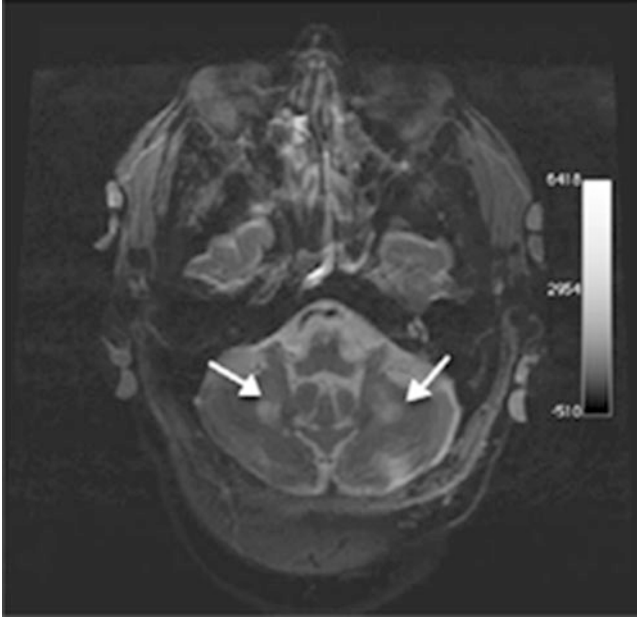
T2-weighted axial image of the brain of a 65 y.o. FXTAS patient with 85 CGG repeats, 15 years of education, and tremor onset at 62 years of age. *Arrows* point to probable spongiform changes in the middle cerebellar peduncles (the “MCP sign”), which appear as white matter hyperintensities. (NINDS grant number NS044299 [JG])
